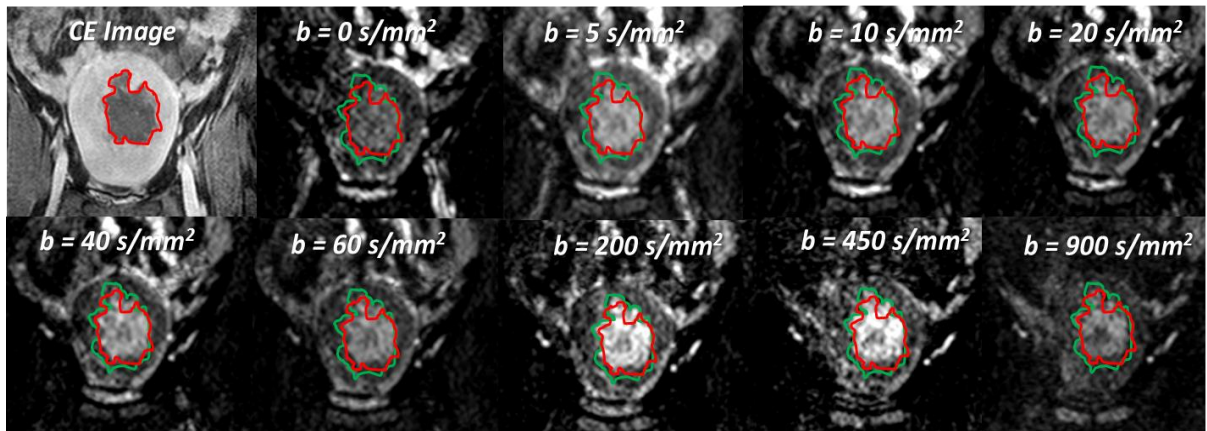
CE image and DWI for patient A after thermal therapy. Coronal views of CE image and DWI with different b values are shown above. The NPV in CE image and DWI are bounded by red and green contour separately.
